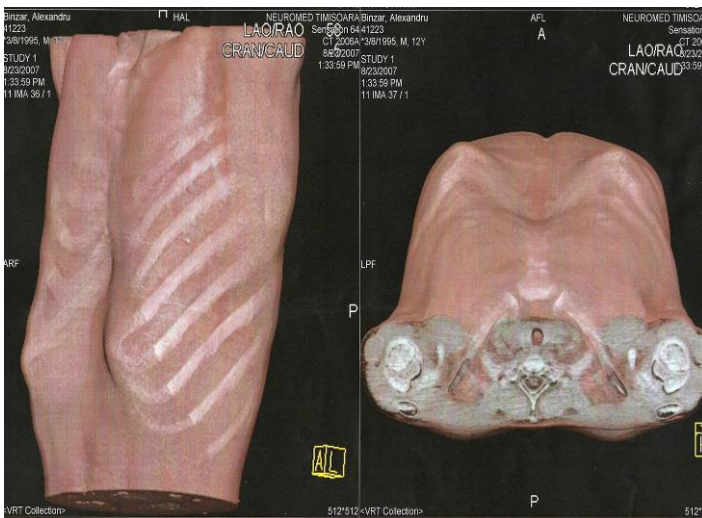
CT scan of the chest confirmed the deformity.
